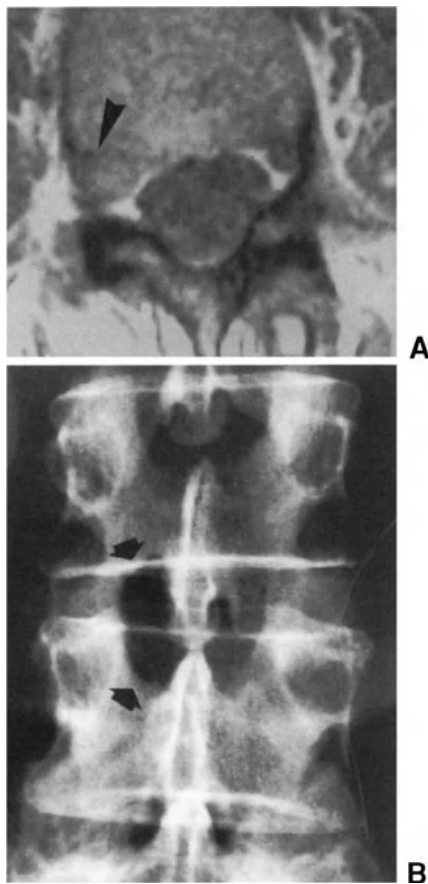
MR image and postoperative radiograph of a patient submitted to microdiscectomy for a migrated herniation at L3-L4 level. (A) MR axial image showing a disc fragment migrated into the proximal portion of the right L3-L4 intervertebral foramen (arrowhead). (B) Extension of laminotomy (arrows) and preservation of the pars interarticularis are visible on postoperative radiograph.
